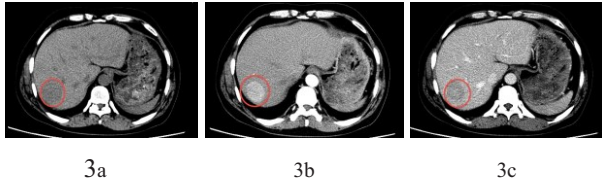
Sample MR images of early stage liver cancer with the ROI selected. Where 3a is the image of  $S_0$ , 3b is image for the  $S_h$  and 3c is the  $S_p$  image.
